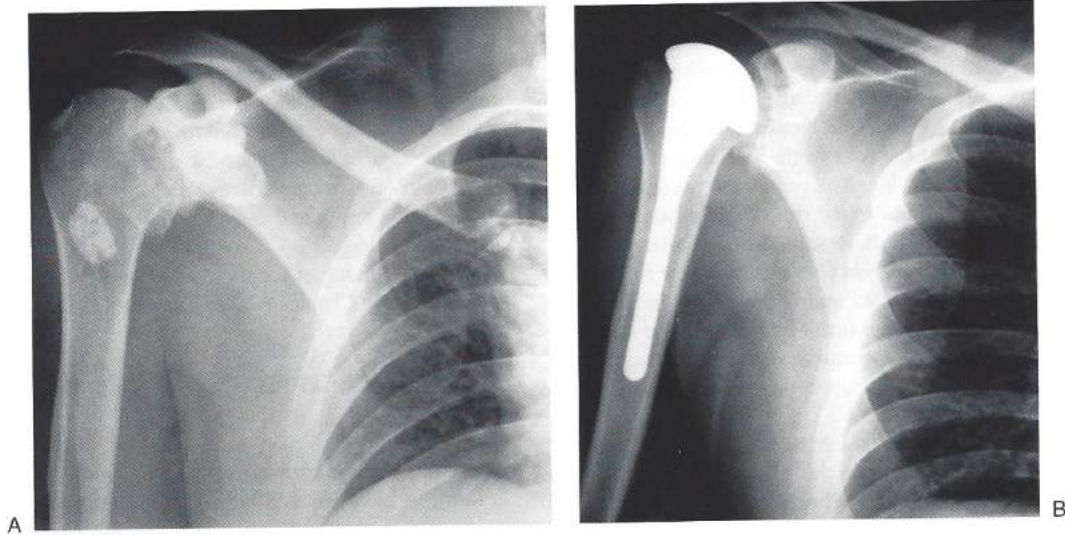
(A) Preoperative anteroposterior roentgenogram showing complete loss of joint space and osteophyte formation. (B) One-year postoperative roentgenogram showing hemiarthroplasty and reconstitution of apparent joint space, demonstrating maintenance of interpositional graft.
